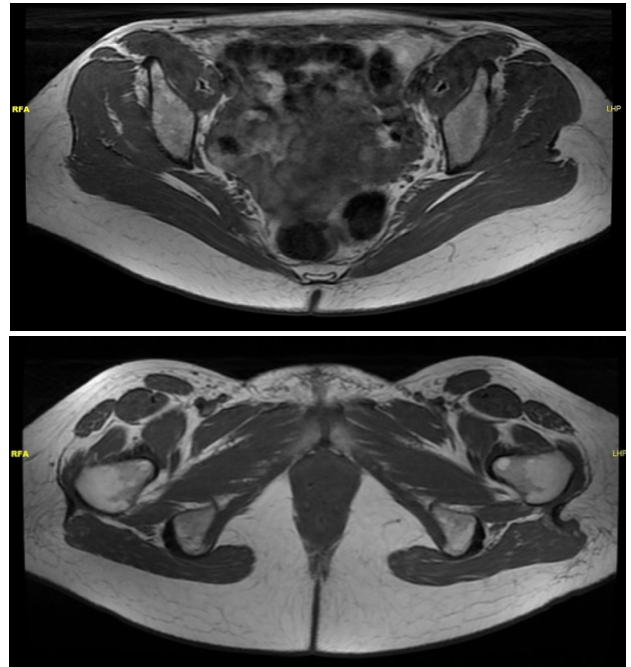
Axial T1-weighted images from mid-gluteal (a) and inferior gluteal (b) levels.
